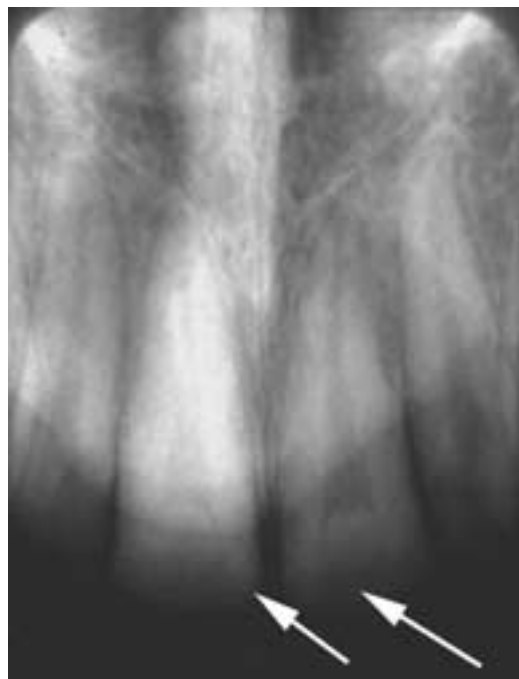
Amelogenesis imperfecta. Periapical view of the anterior maxilla. Dentin, pulp chamber, and cementum are present, but there is no or very thin enamel (arrows).
